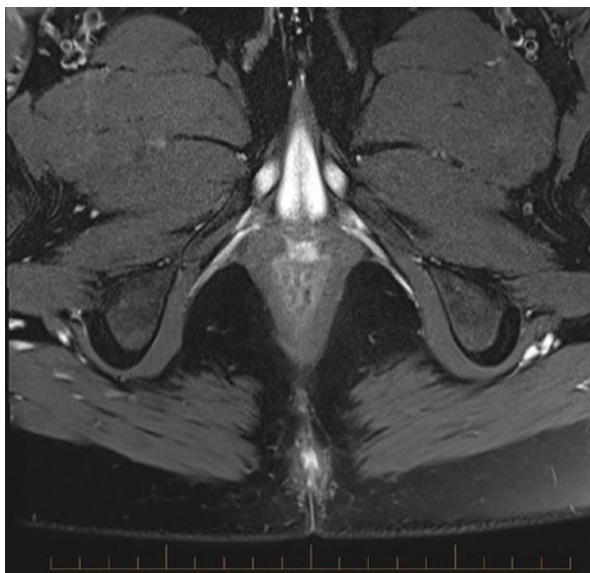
Axial MR image—secondary track with abscess directed posteriorly in the right ischioanal fossa
